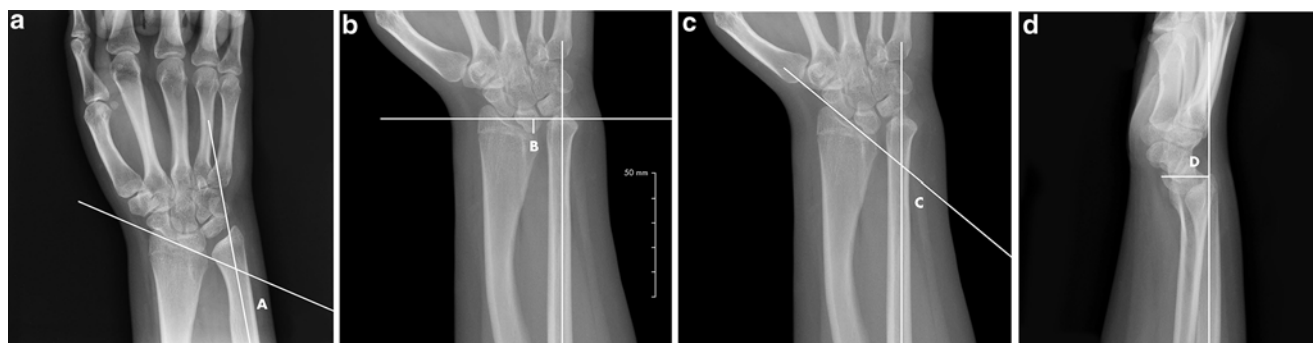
Radiographic parameters of Madelung deformity. (a) (Ulnar tilt): Ulnar tilt is defined on the PA X-ray as the complement (90°-angle A) of the acute angle (angle A) between the longitudinal axis of the ulna and a line tangential to the proximal surfaces of the scaphoid and lunate. (b) (Lunate subsidence): Lunate subsidence on a PA X-ray is defined as the distance in millimeters (distance B) between the most proximal point of the lunate and a line perpendicular to the longitudinal axis of the ulna and through its distal articular surface. The measurement is positive if the ulna extends distal to the proximal surface
